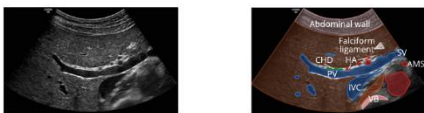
Ultrasound images of the liver hilus Left Image: Legend see above. Right: Following
